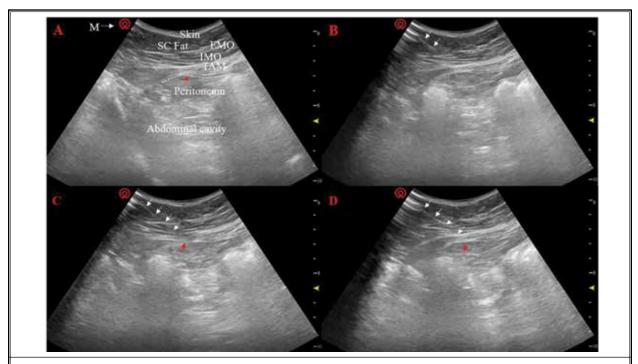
(A) Preinjection short axis sonogram showing the abdominal wall anatomic layer. The dotted line shows the peritoneum. The arrow indicates the position of the peritoneum. (B) The arrow indicates the position of the puncture needle. (C) The white arrow displays the position of the puncture needle, and the red arrow indicates the area where the needle tip reaches the peritoneum. (D) The white arrow reveals the position of the puncture needle, and the red arrow indicates the possible area where the needle tip is located (needle tip is not shown in the ultrasound images). M = transducer probe marking; SC Fat = subcutaneous fat; EMO = external oblique muscle; IOM = internal oblique muscle; TAM = transversus abdominis muscle.
